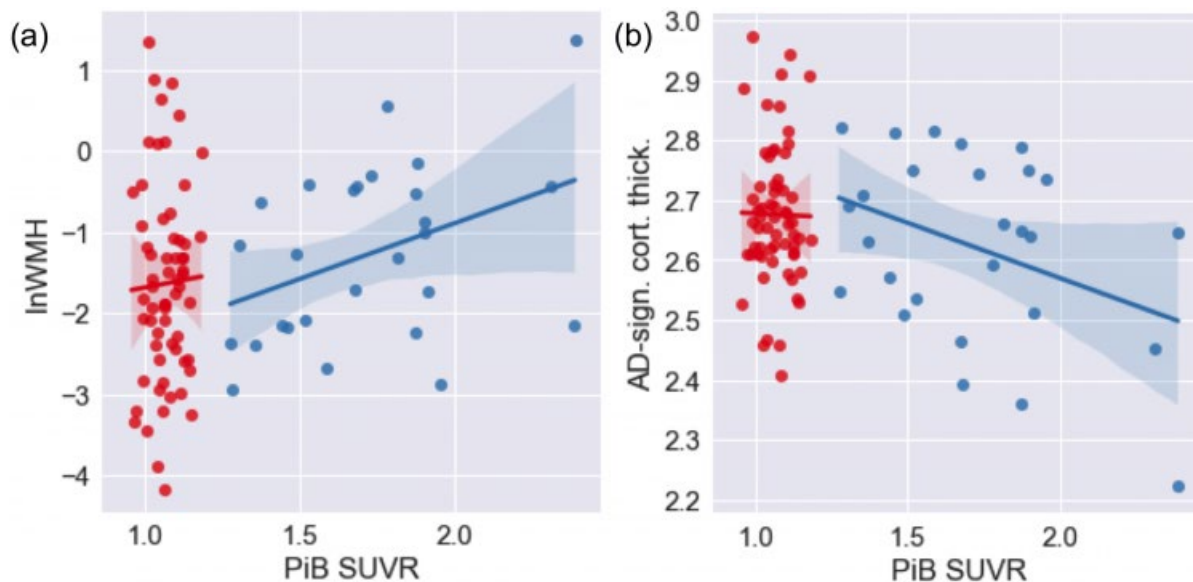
(a) PiB SUVR (x) vs. log-norm. WMH volume (y). (b) PiB SUVR (x) vs. AD-signature cortical thickness (y). PiB- subjects in red; PiB+ in blue.
